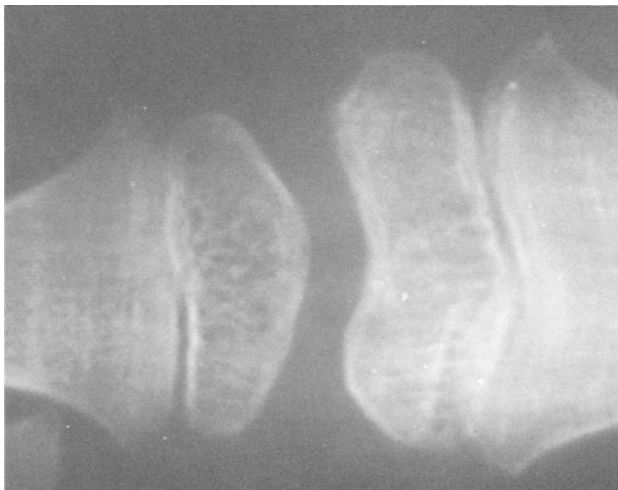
X-radiograph of the distal femur and proximal tibia and fibula.*
